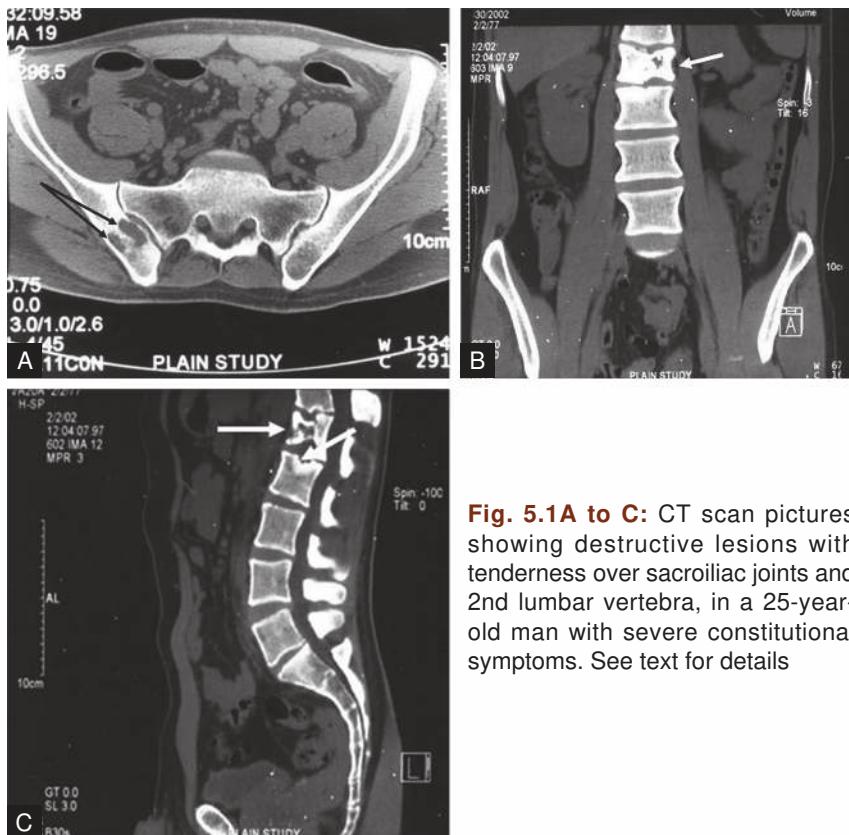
to C: CT scan pictures showing destructive lesions with tenderness over sacroiliac joints and 2nd lumbar vertebra, in a 25-year-old man with severe constitutional symptoms. See text for details
